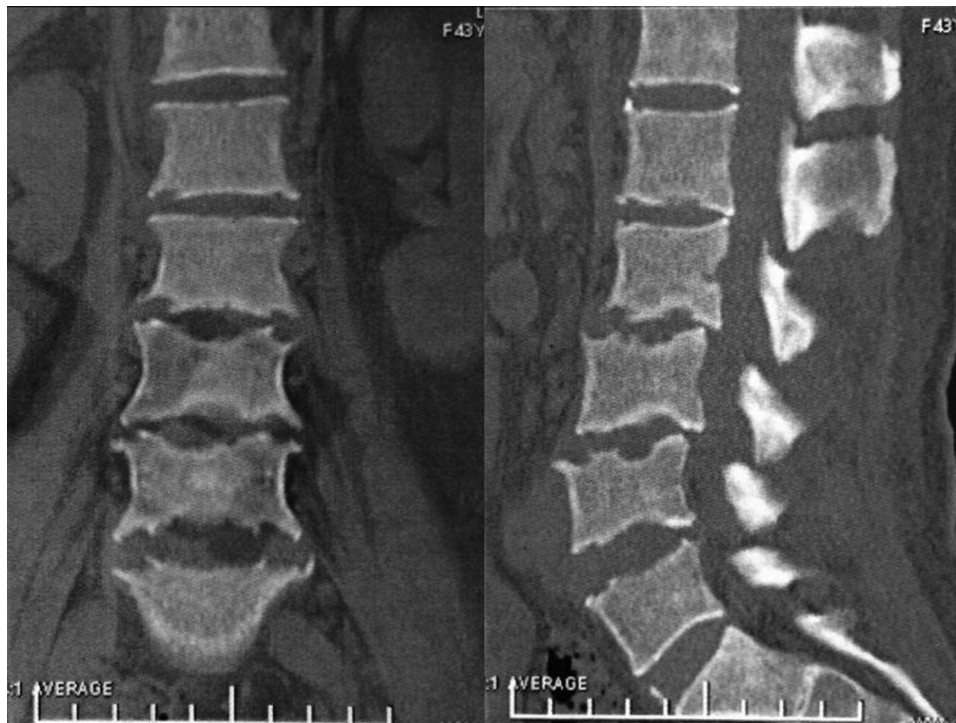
Coronal and sagittal three-dimensional computed tomographic image showed moth-eaten destruction of upper and lower end plates of all lumbar vertebral bodies and unsatisfactory sagittal lumbar alignment.
